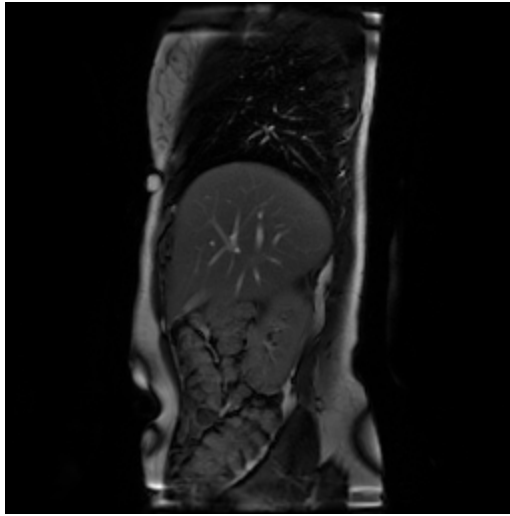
An example of the diaphragm screened by MRI in a sagittal plane.
